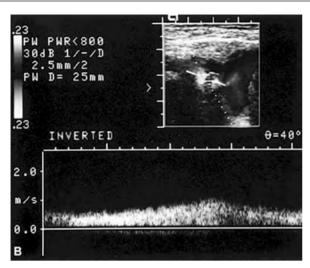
Pulsed doppler from the subclavian vein distal to thrombosis showing continuous flow with loss of respiratory and cardiac phasicity.
